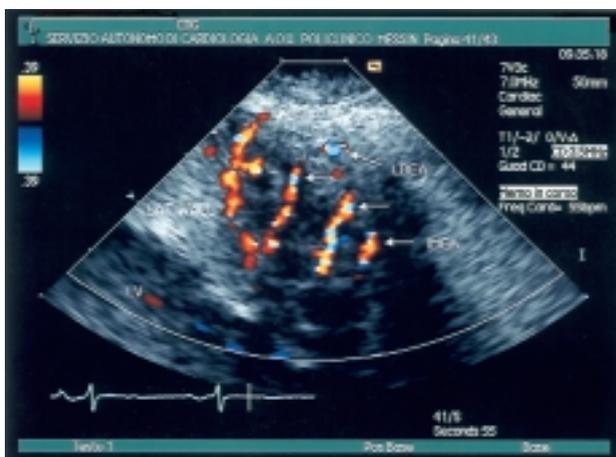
Modified apical 4-chamber view, with magnification of the lateral wall (left panel) in patient E. In this frame, the intramyocardial coronary artery (IMCA) flow was assessed by means of a high-frequency transducer and standard color Doppler analysis. The diastolic peak velocity reaches 137 cm/s and the systolic component is inverted. It is noteworthy that the atrial systolic contribution seems to modify the coronary diastolic slope (right panel). Two-dimensional image settings: transducer frequency 7 MHz; depth 50 mm; velocity range 39 cm/s; gain 44 dB. LDCA = left anterior descending coronary artery; LV = left ventricle.
